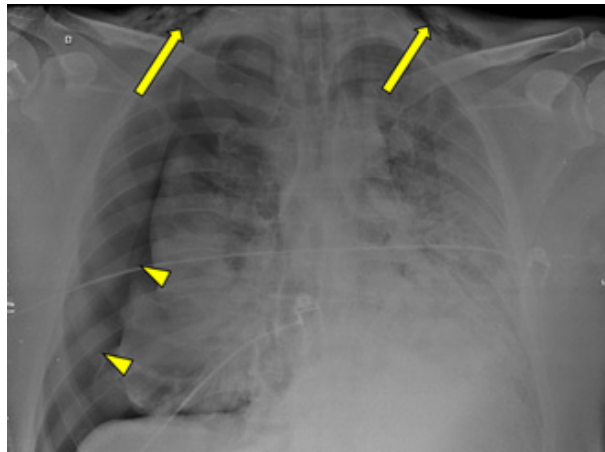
On day 8, a control chest X-ray performed short after intubation found cervical subcutaneous emphysema (arrows) and a large pneumothorax on the right with subtotal lung collapse (arrowheads), requiring surgical chest tube placement.
